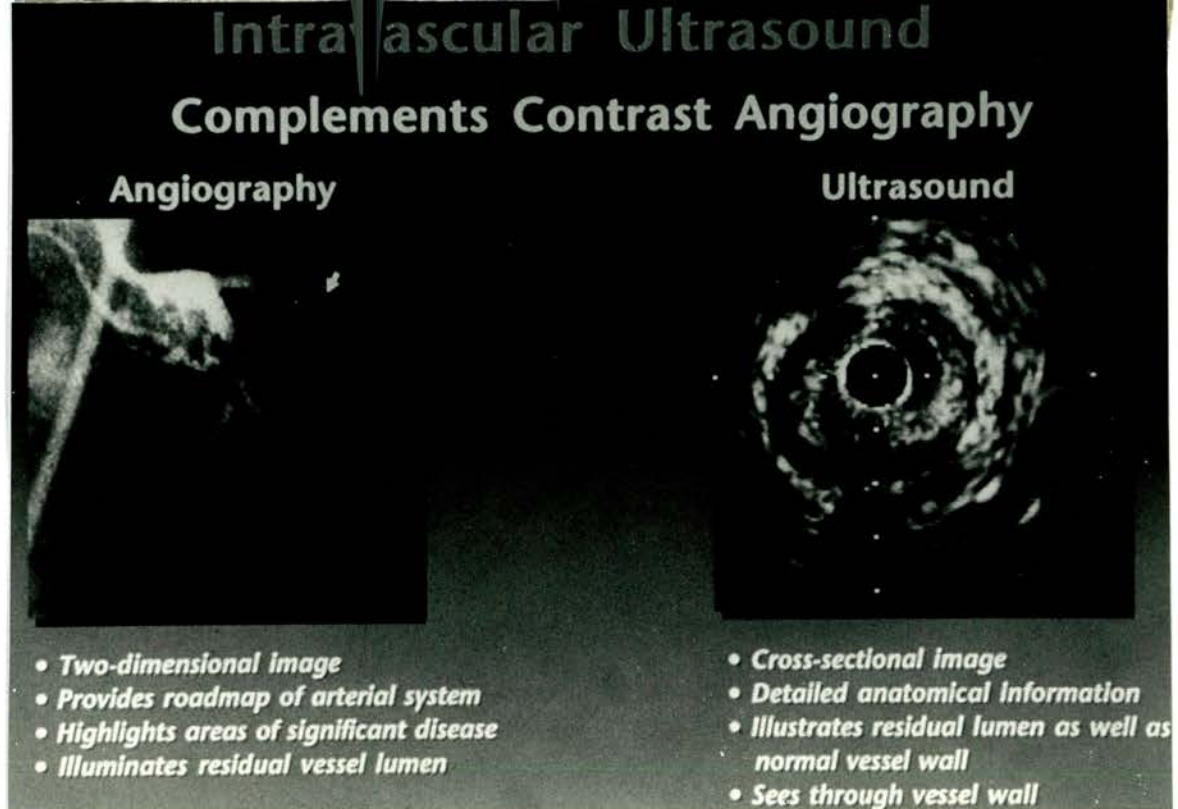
Comparison of intravascular ultrasound with angiography. Whereas angiography shows the stenosis, intravascular ultrasound also gives information about plaque morphology, percent stenosis and the effects of angioplasty on the vessel wall.
